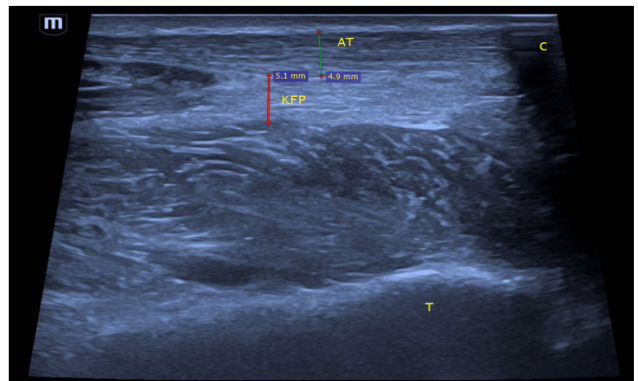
Ultrasound measurement of Achilles tendon (AT) and Kager's fat pad (KFP) thickness. (AT: Achilles Tendon; KFP: Kager's Fat Pad; C: Calcaneus; T: Tibia.)
